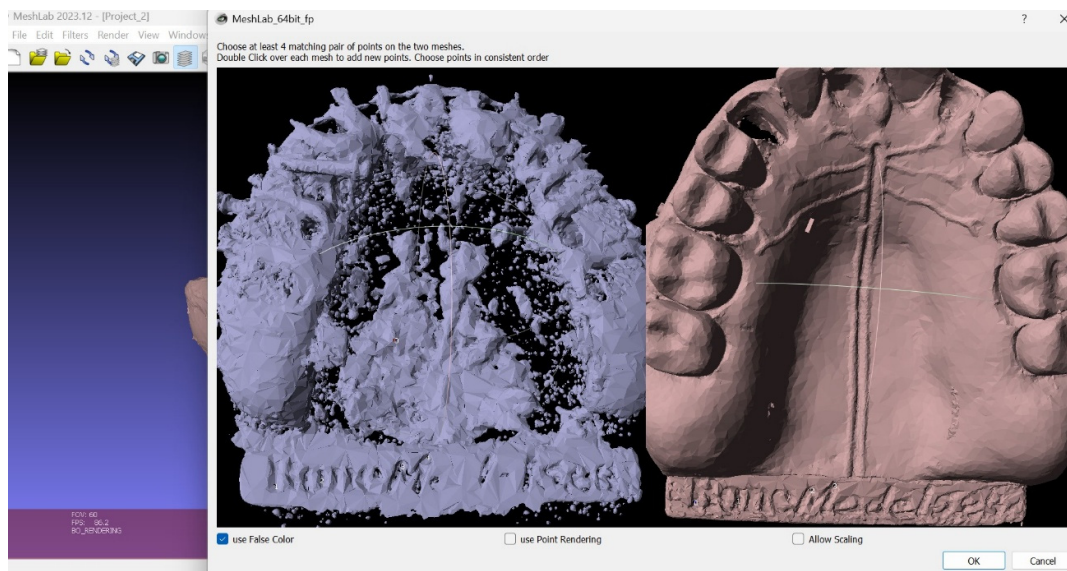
CBCT and STL exported from the X-Guide<sup>®</sup> software to STL format.
